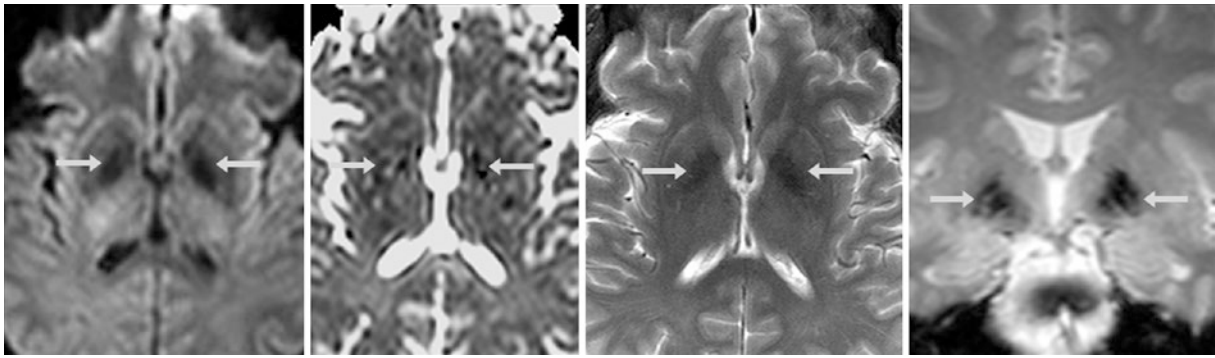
A 3 T MRI from a 62-year-old demonstrates a mild degree of T2 blackout (*arrows*) on DWI (*left*), ADC map (*left middle*), T2WI (*right middle*), and coronal gradient-echo T2*WI (*right*). The blackout
